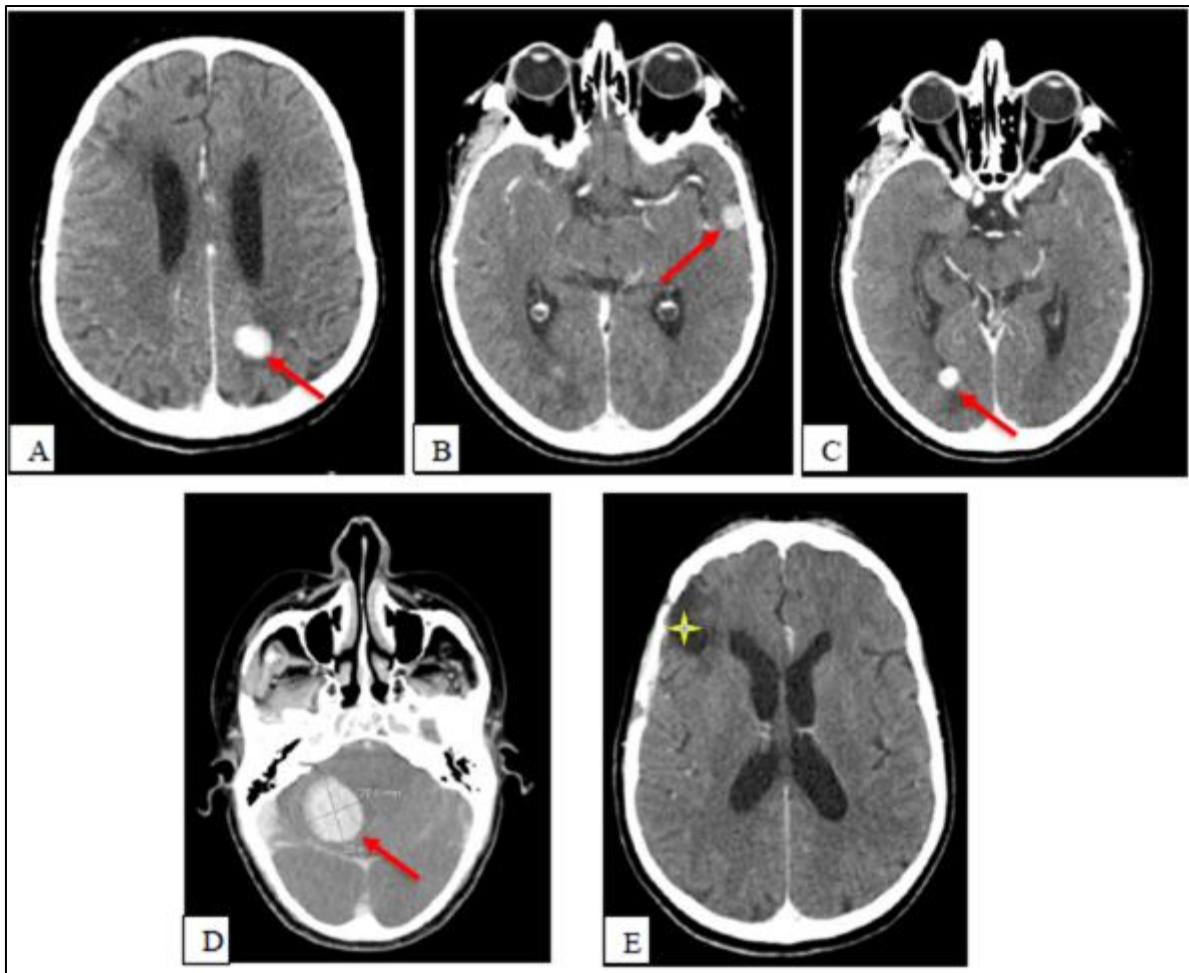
Baseline contrast-enhanced brain CT (axial views). Multiple enhancing lesions are identified in both intra- and extra-axial compartments, consistent with metastatic disease. Four well-defined, oval lesions show homogeneous contrast enhancement and are surrounded by vasogenic edema, including a left parietal lesion (A, red arrow), a lesion adjacent to the right occipital horn (B, red arrow), a right anterior temporal lesion (C, red arrow), and a larger extra-axial lesion along the right cerebellar tentorium (D, red arrow), measuring approximately 30 × 35 mm. A right fronto-subcortical hypodense area (E, yellow star) corresponds to postoperative changes at the prior metastasectomy site.
